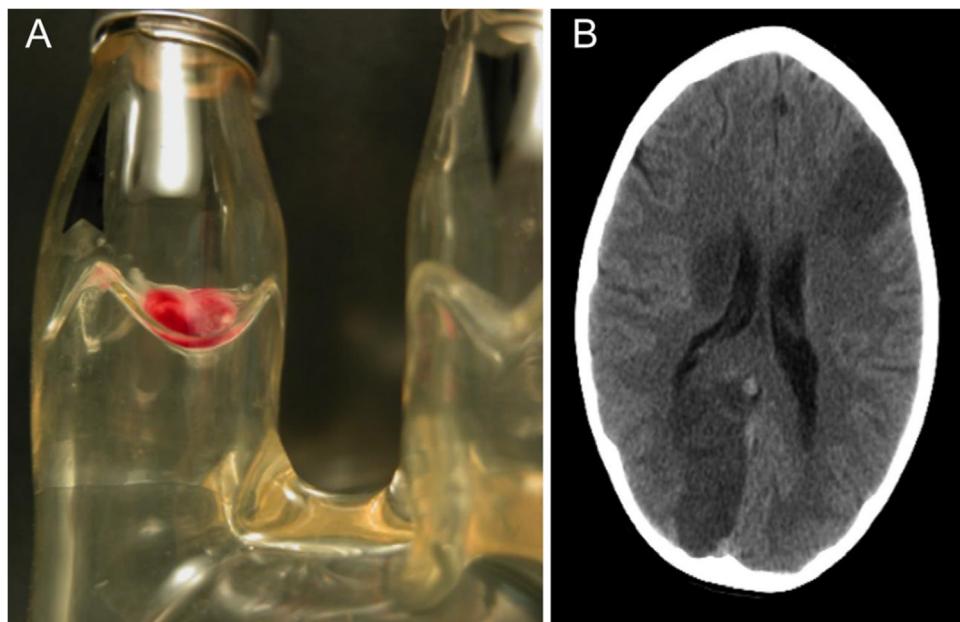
(A) Thrombus located on the outflow valve of a Berlin Heart EXCOR pediatric LVAD. (B) Computed tomography image of a child with embolic stroke on EXCOR support.
